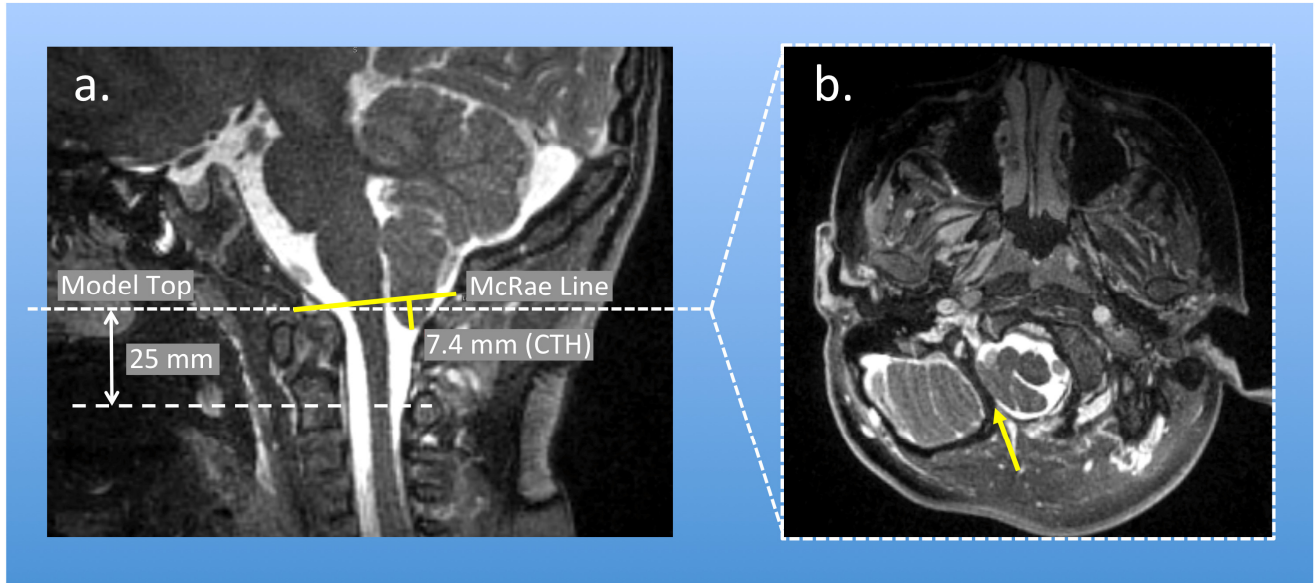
a) Midsagittal MRI image of the cervical spine of a CMI patient showing the cerebellar tonsillar herniation (approximately 7.4mm); (b) transverse MR image from the plane used to separate the top of the 3D model that was reconstructed, highlighting the separation between the cerebellar tonsils and body of the cerebellum⁶⁴.
